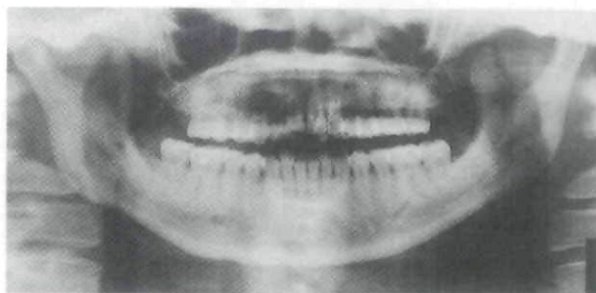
Panoramic radiograph of the patient at age of 18 years. (at initial visit).
